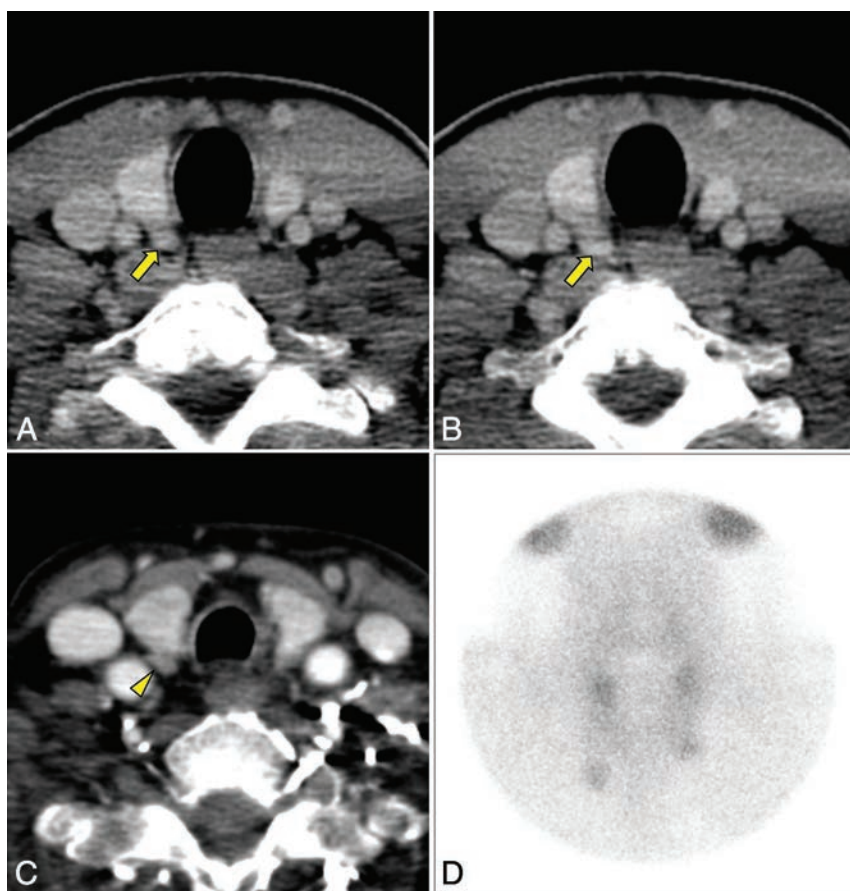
Comparison of clinically acquired axial CT images between the ZT appearing discontinuous from the thyroid gland and as a separate nodule or lymph node. A, Contrast-enhanced CT scan of a 33-year-old male patient who had undergone neck CT for work-up of lymphoma. There is a bulging structure (*arrow*) at the posterior aspect of the right thyroid lobe, and a fat plane between this structure and the thyroid lobe. The bulging structure protrudes toward the posterior and medial direction. The fat plane is not evident at the lower level of the CT image (B), which means that the bulging structure is a ZT protruding in the posteromedial and superior direction. C, Contrast-enhanced CT scan of a 65-year-old female patient who had hyperparathyroidism. An oval nodular lesion (*arrowhead*) separated from the thyroid gland with a fat plane is seen posterior to the right thyroid lobe and is protruding in the posterior and lateral direction. This nodule is suggested to be a parathyroid adenoma or hyperplasia in the delayed image of the parathyroid scan (D).
